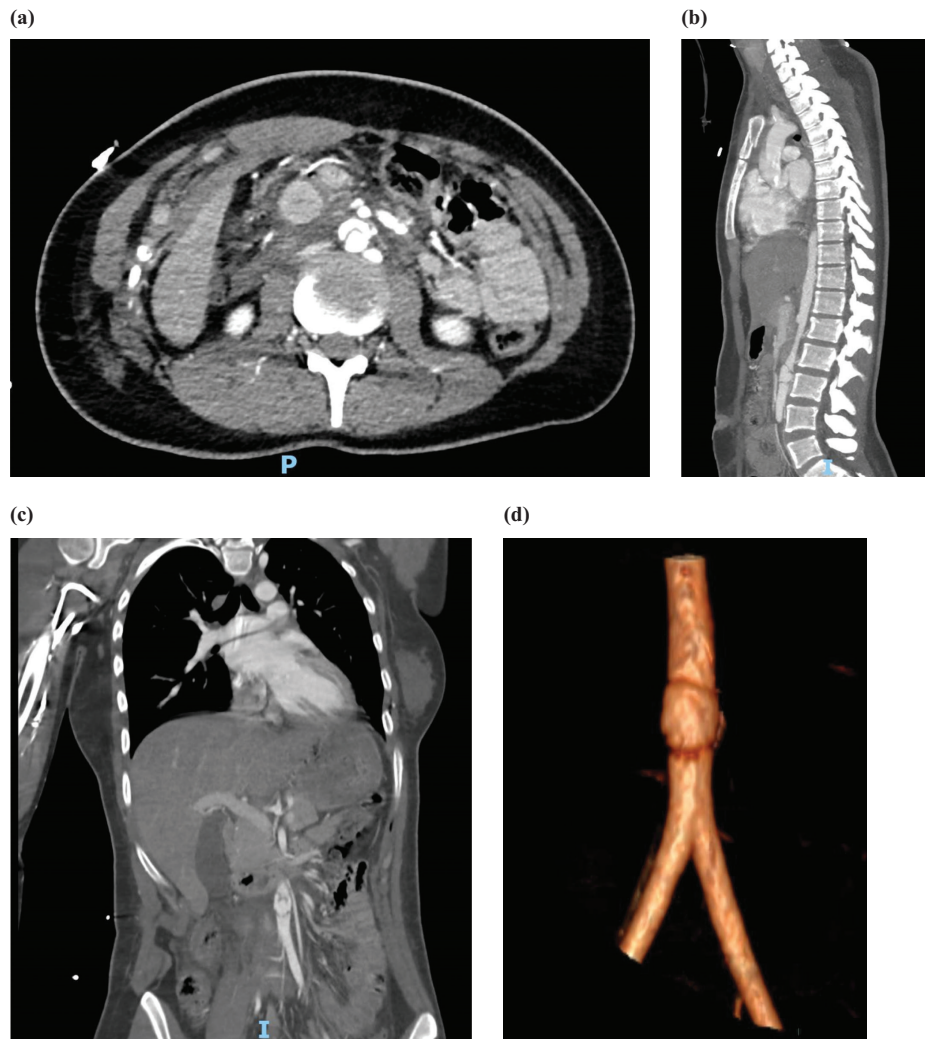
(a) Abdominal CT scan, axial view. (b) Abdominal CT scan, sagittal view. (c) Abdominal CT scan, coronal view. (d) 3D reconstruction of the infra-renal aorta.
